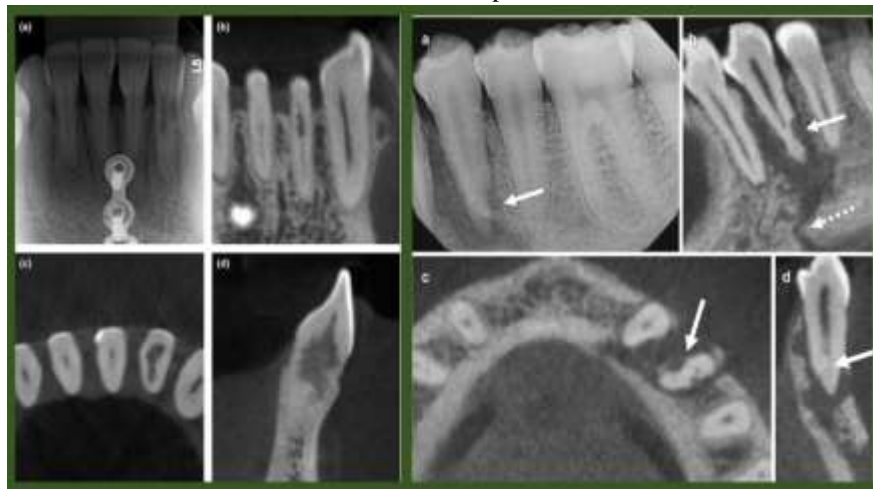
Method of Detecting Tooth Root Erosion Using CT scan and Radiation after Receiving Orthodontic Treatment
